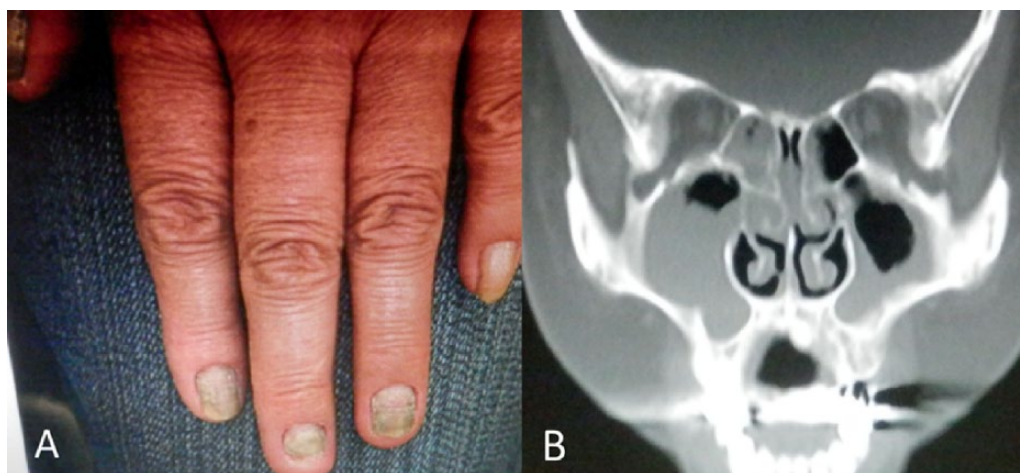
Preoperative fingernails and sinus computed tomographic scans are observed on both hands. (A) Yellowing and thickening of the fingernails are observed on both hands. (B) Homogenous soft tissue densities are seen around the maxillary and ethmoid sinuses on both sides. No clear bone loss or destruction is observed.
